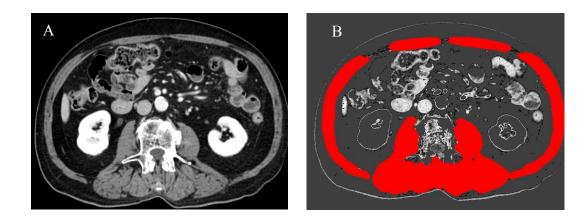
Method for measuring skeletal muscle mass at 3<sup>rd</sup> lumbar vertebra. (A) The computed tomography image taken from the PACS and saved in DICOM format. (b) The image is post processed using in-house developed software for calculation of cross-sectional area of abdominal wall muscles as delineated in red. The sum of the muscle areas is calculated as 3<sup>rd</sup> lumbar vertebra skeletal muscle area (L3SMA).
